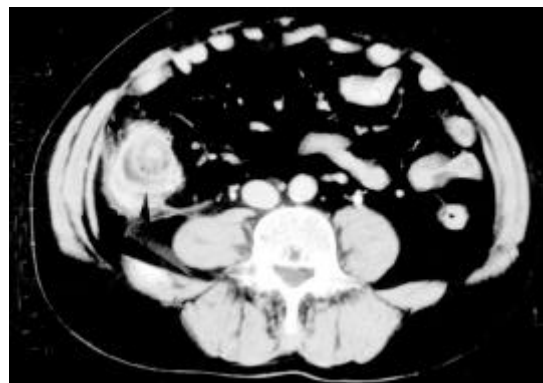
Acute diverticulitis of cecum in 50-year-old man. CT scan clearly showed enhancement of thickened diverticular wall and preservation of wall enhancement pattern of cecum as hyperattenuating inner layer, thickened middle layer of low attenuation, and outer high-attenuation layer (black arrow head).
